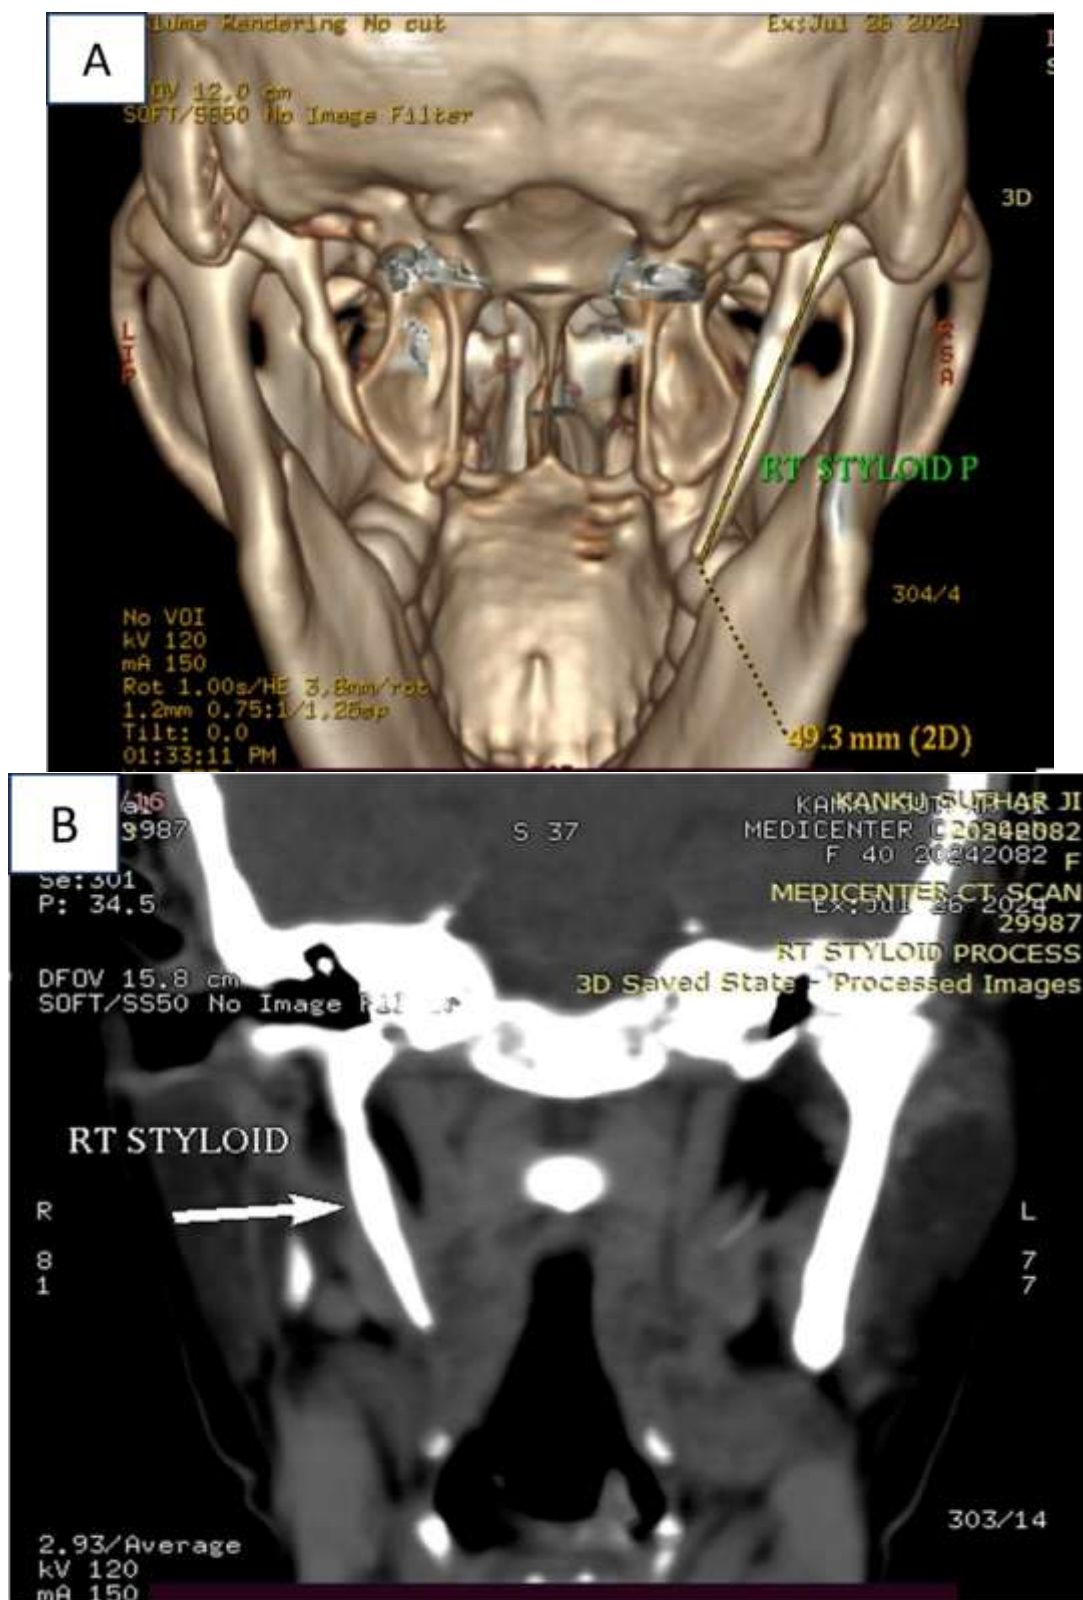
Pre-operative CT Scan
